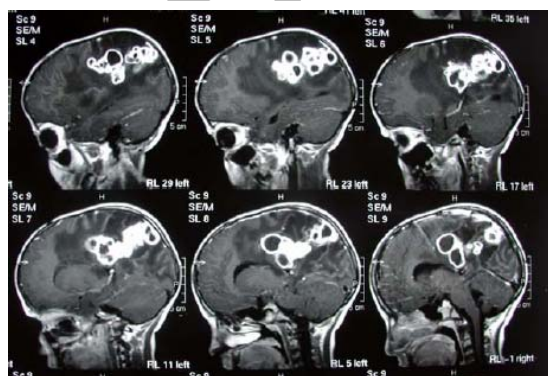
Brain MRI (sagittal view) of tuberculous brain abscess of a child with cystic fibrosis
